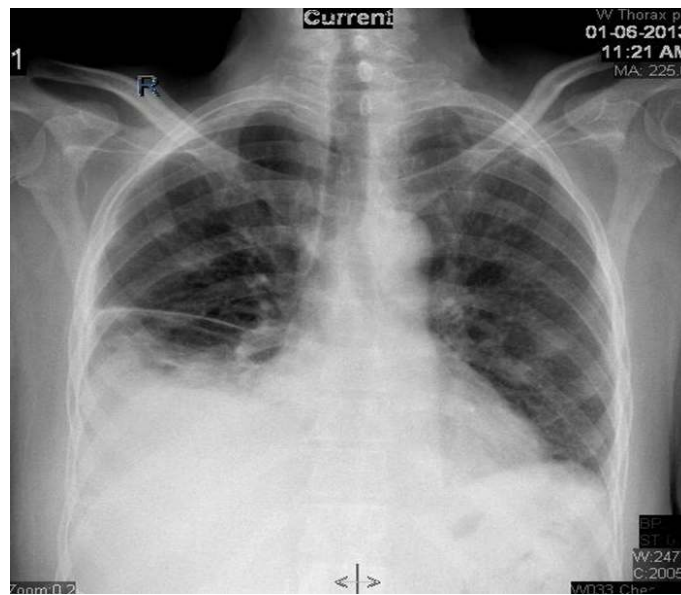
Chest X-ray showing a heterogeneous opacity involving the mid and lower zone on the right side along with obliteration of the right costophrenic angle and an airbronchogram, suggestive of a parapneumonic effusion
